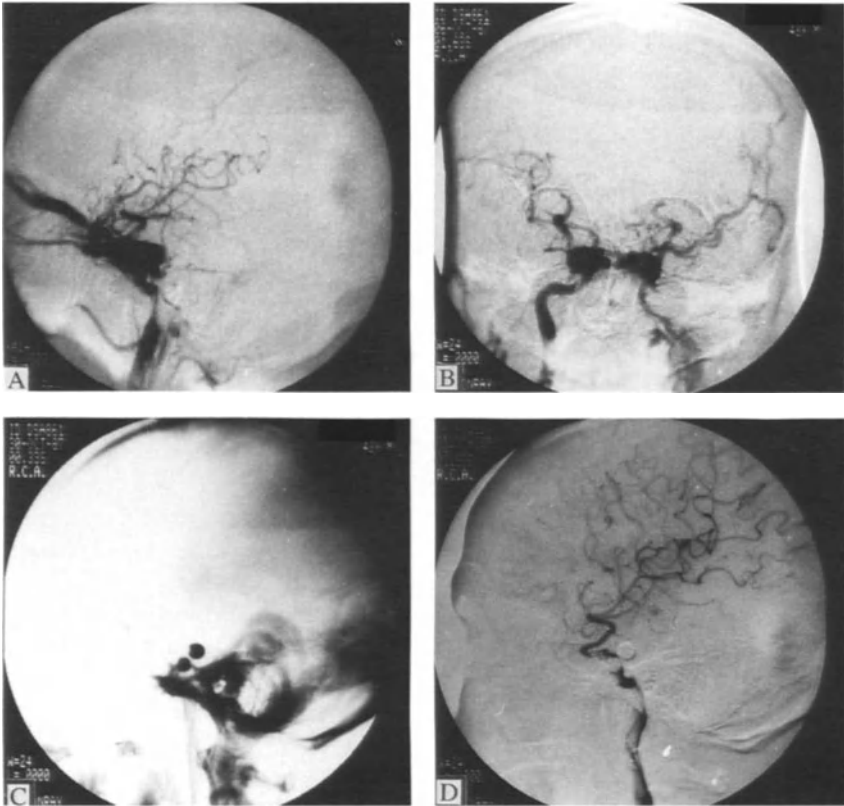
TCCF. (A&B) Preembolization angiograms showing mixed venous drainage. (C) Postembolization plain film showing two balloons placed in the cavernous sinus (D) Postembolization angiogram shows that the TCCF is no longer visualized and the ICA is preserved.
